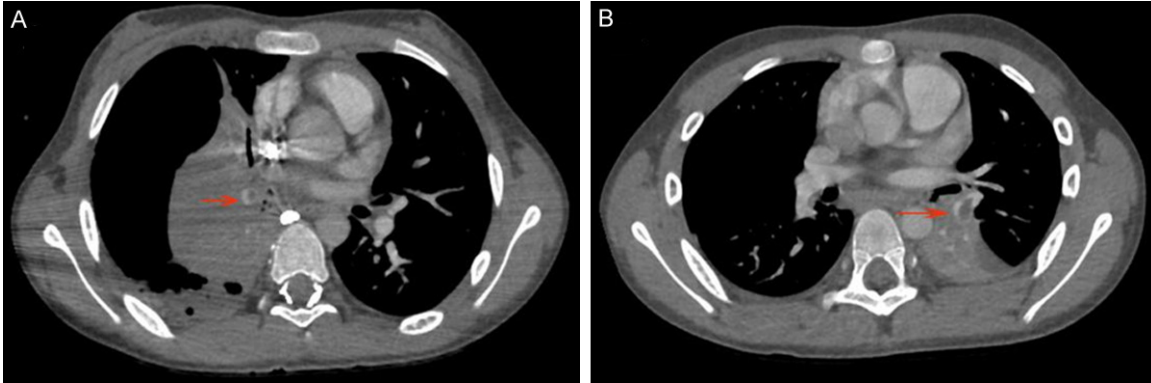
CTA of the two cases. A. Pulmonary emboli in branches of the right lower pulmonary artery (arrow) and an encapsulated hydro-pneumothorax; B. Pulmonary emboli in the distal branches of the left lower pulmonary artery (arrow) and left lower lobe consolidation.
